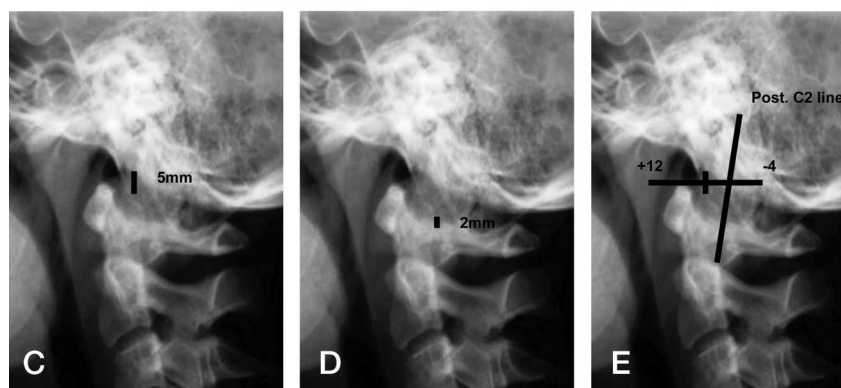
Methods to diagnose AOD shown on plain radiographs of a patient without injury. A, Power's ratio-line segments BC/OA, 40/46 mm = 0.87. B, X-line method. Posterior-superior aspect of dens and spinolaminar line at C1 are intersected. C, Basion-dens interval <10 mm. D, Condylar gap, 2 mm with no displacement. E, Harris method. Basion-dens interval of 5 mm with no displacement.
